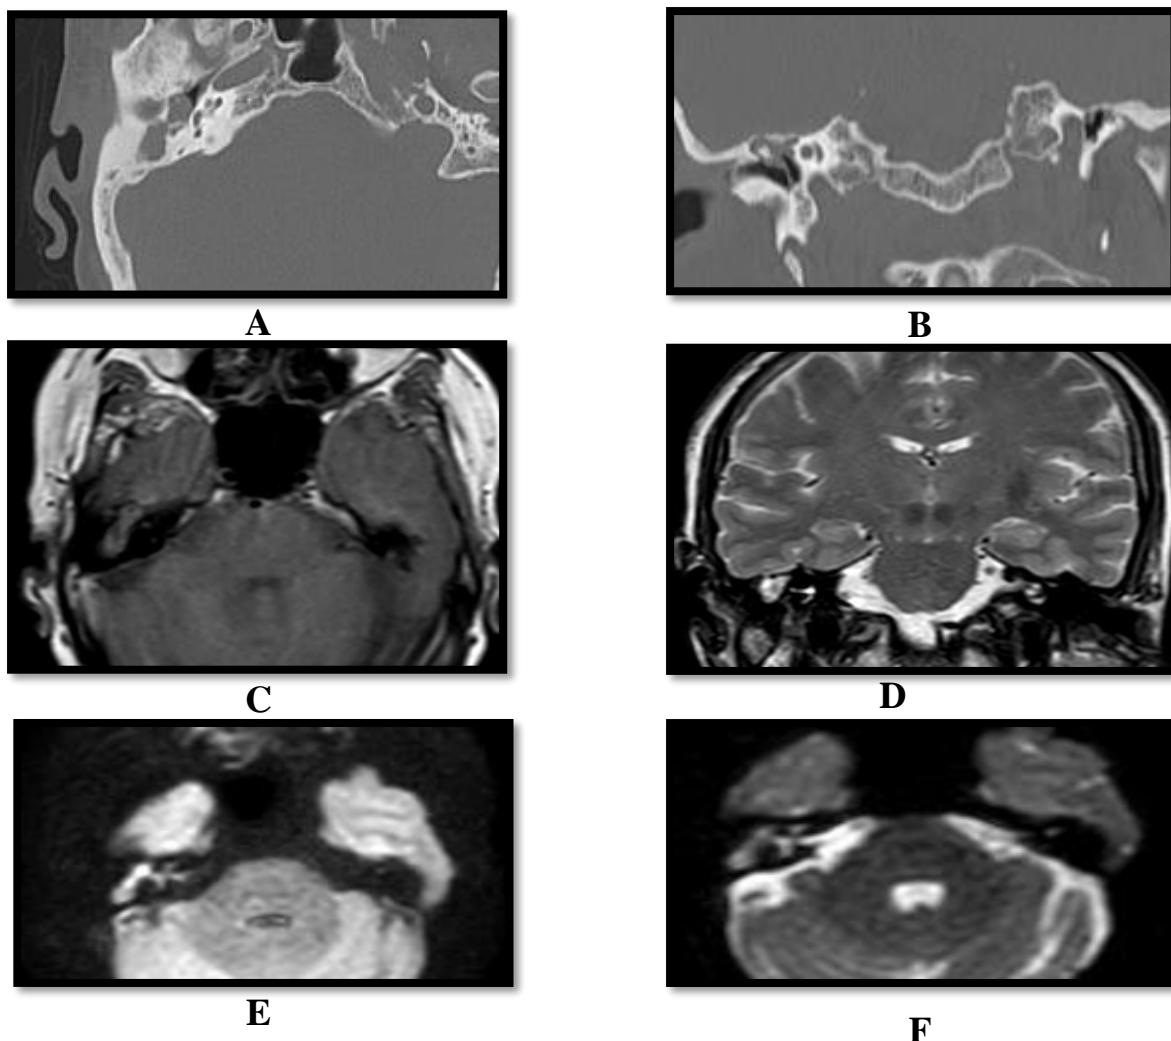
A 51-year-old female, complaining of right painless otorrhea. CT and MRI were requested. [A], [B]: axial & coronal CT petrous bone: showing soft tissue density almost obliterating the right middle ear cavity, with opacification of right mastoid air cells, with no evidence of ossicle erosions or intracranial extension, tegmentum tympani is intact. [C]: Axial T1 WI: showing iso intense soft tissue signal occupying the right middle ear cavity. [D]: coronal T2 WI: the lesion eliciting high SI. [E]: DWI: the lesion shows high SI which representing restricted diffusion. [F]: ADC map: the lesion eliciting hpo SI.
